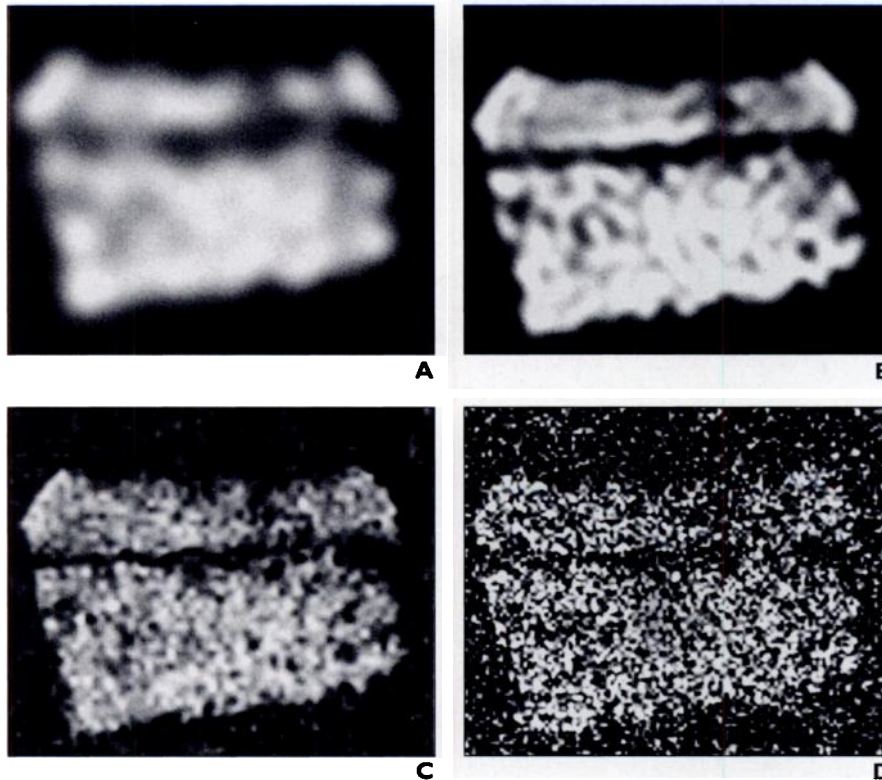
MR images show effect of signal-to-noise ratio (SNR) with decreasing pixel sizes at 1.5 T.
